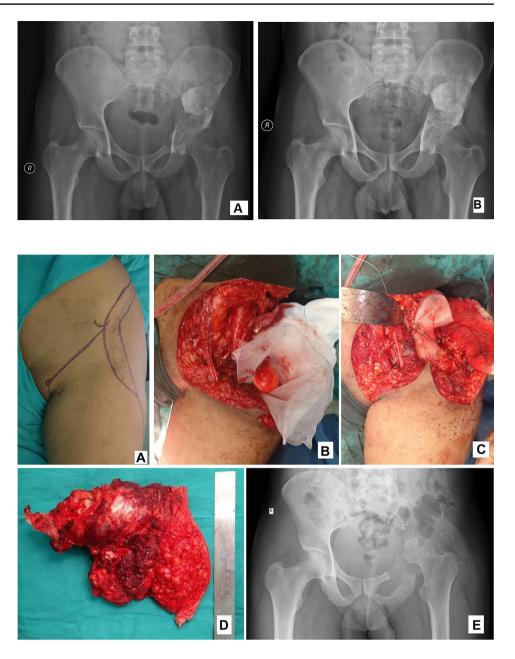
a Radiograph of the pelvis before administration of zoledronic acid showing extensive lysis in the supra-acetabular region. b Radiograph following administration of two doses of zoledronic acid at four weekly interval showing ossification in the supra-acetabular region
